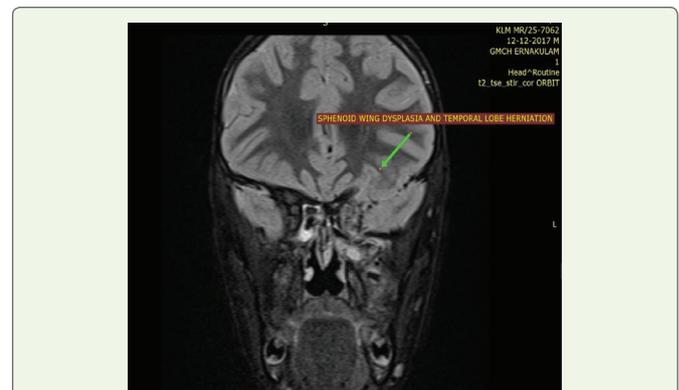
MRI orbit, coronal T2-weighted image of an 8-year-old boy suspected to have NF-1 demonstrates anterior herniation of the left temporal lobe into the posterior portion of the left orbit, consistent with an orbital encephalocele, resulting in left-sided proptosis and mild asymmetric enlargement of the left globe.
